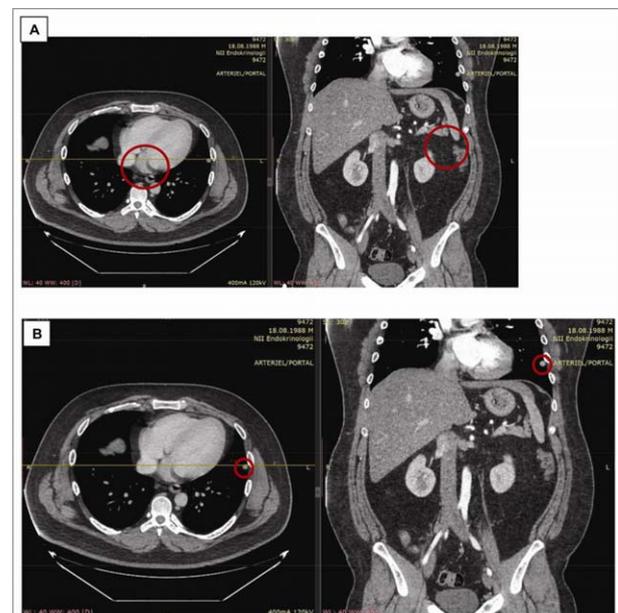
CT of the Abdomen, Pelvis and Chest. CT images show lung (Panel B) and multiple para-aortic lymph node (Panel A) metastasis.
